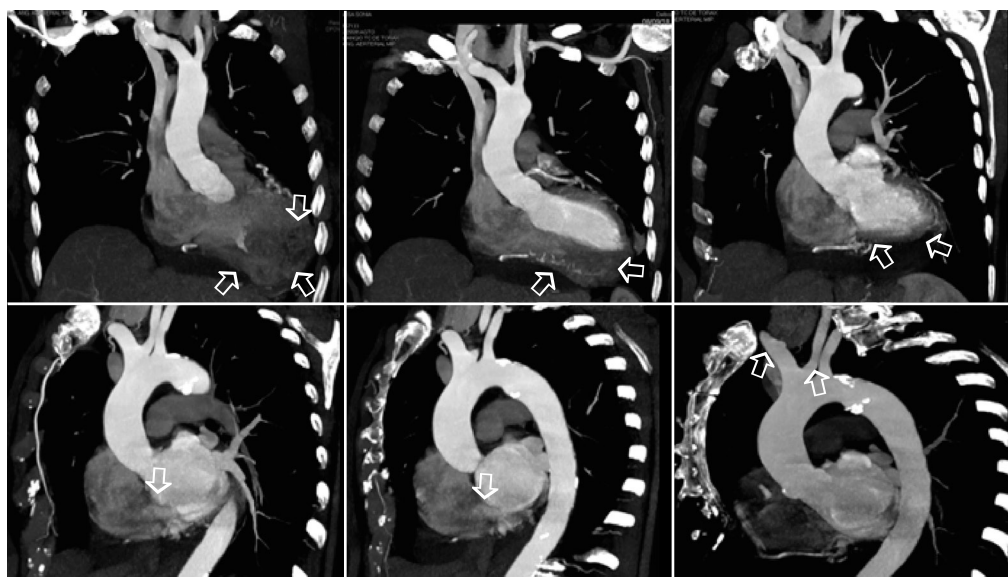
MDCT angiography: the bulky and poorly delimited infiltrative lesion (white arrows) affecting the RV, notably its tip and its lateral and anterior walls, as well as the distal interventricular septum, extending through the whole myocardium thickness with protrusion into the pericardial space, associated to moderate pericardial effusion. MDCT, multidetector computed tomographic; RV, right ventricle.
